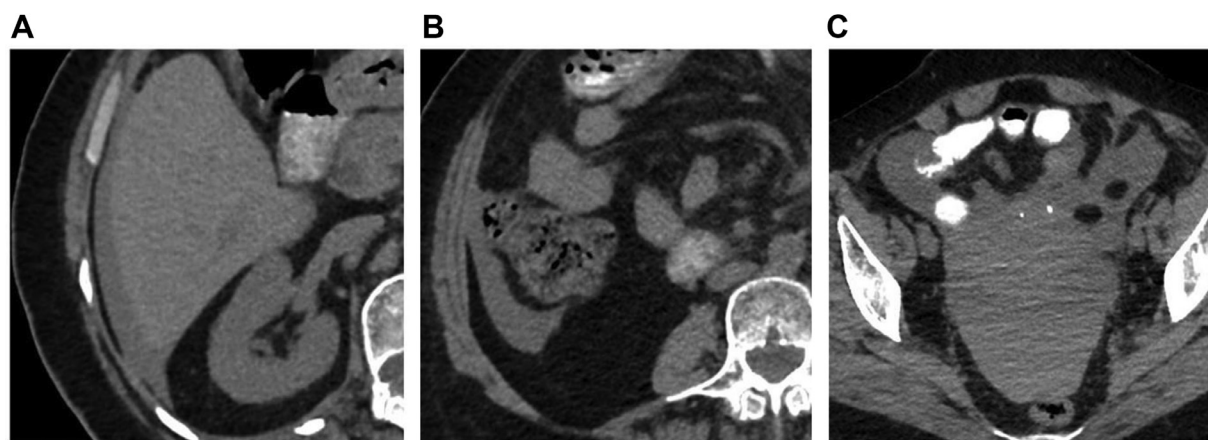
Axial plain CT images show mildly high attenuation (average ± 30 HU) perihepatic (A), right paracolic (B) and pelvic free fluid (C).
